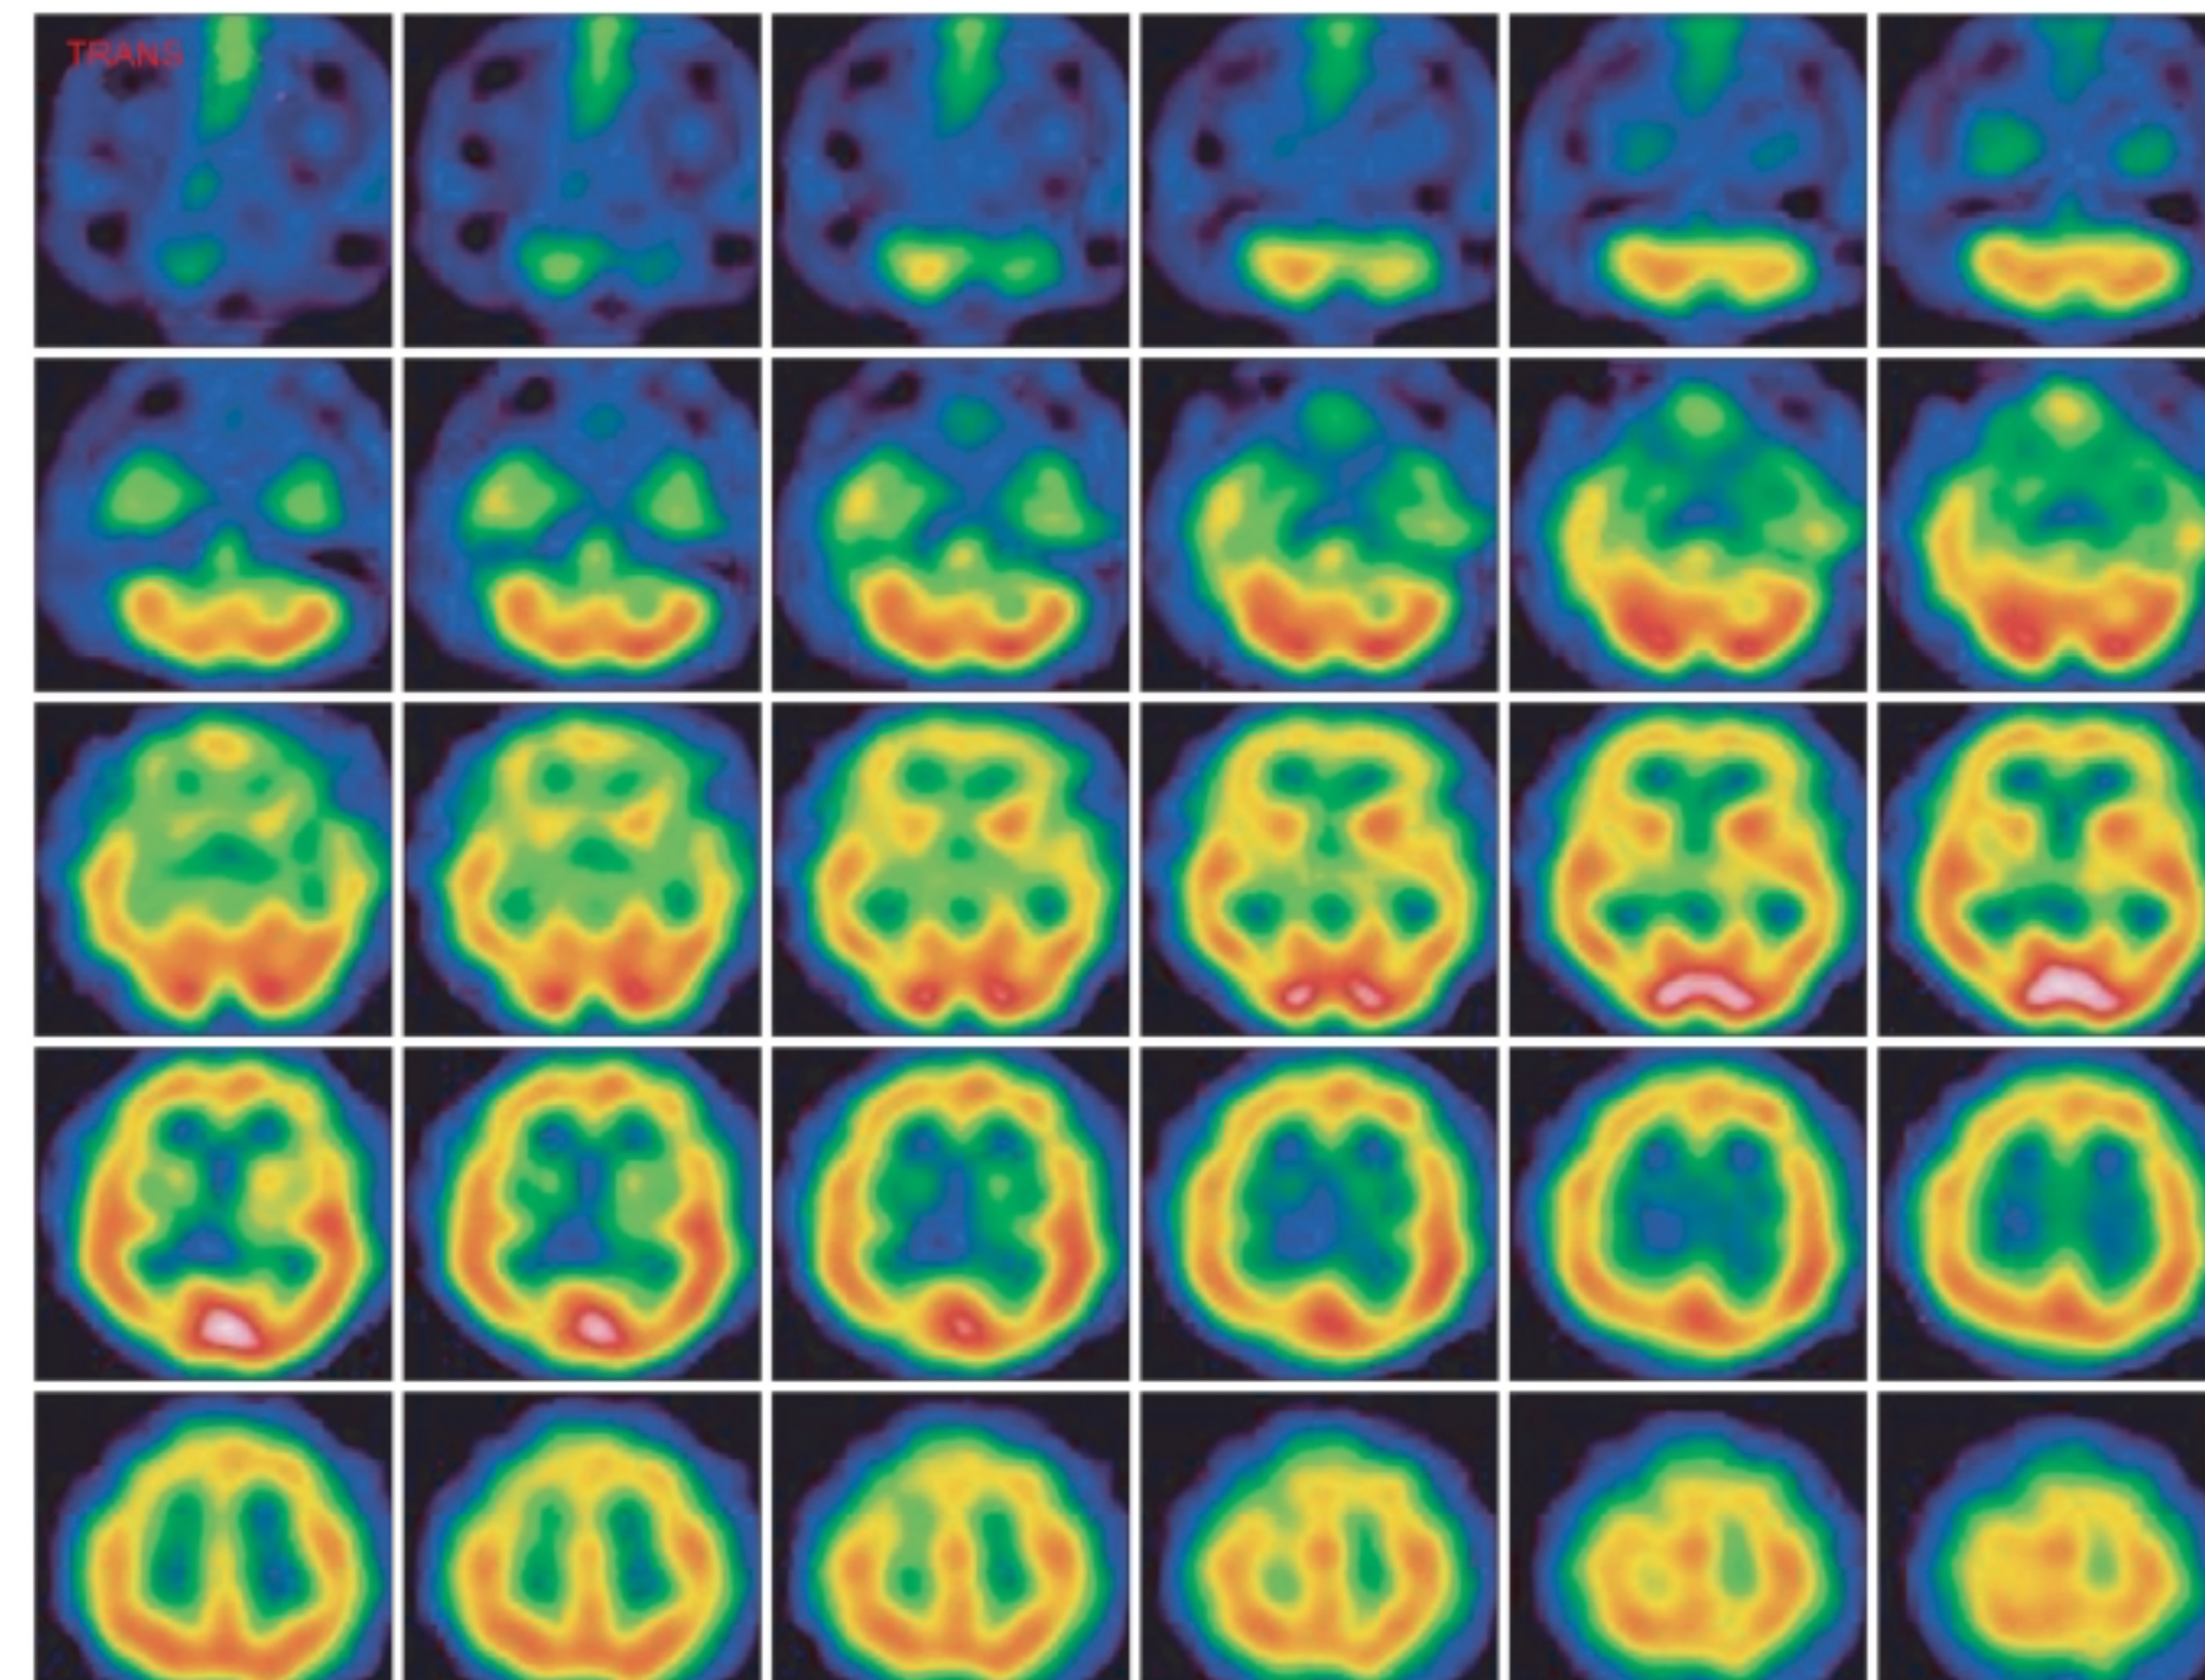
Single photon emission computed tomography (SPECT) showing decreased perfusion.
